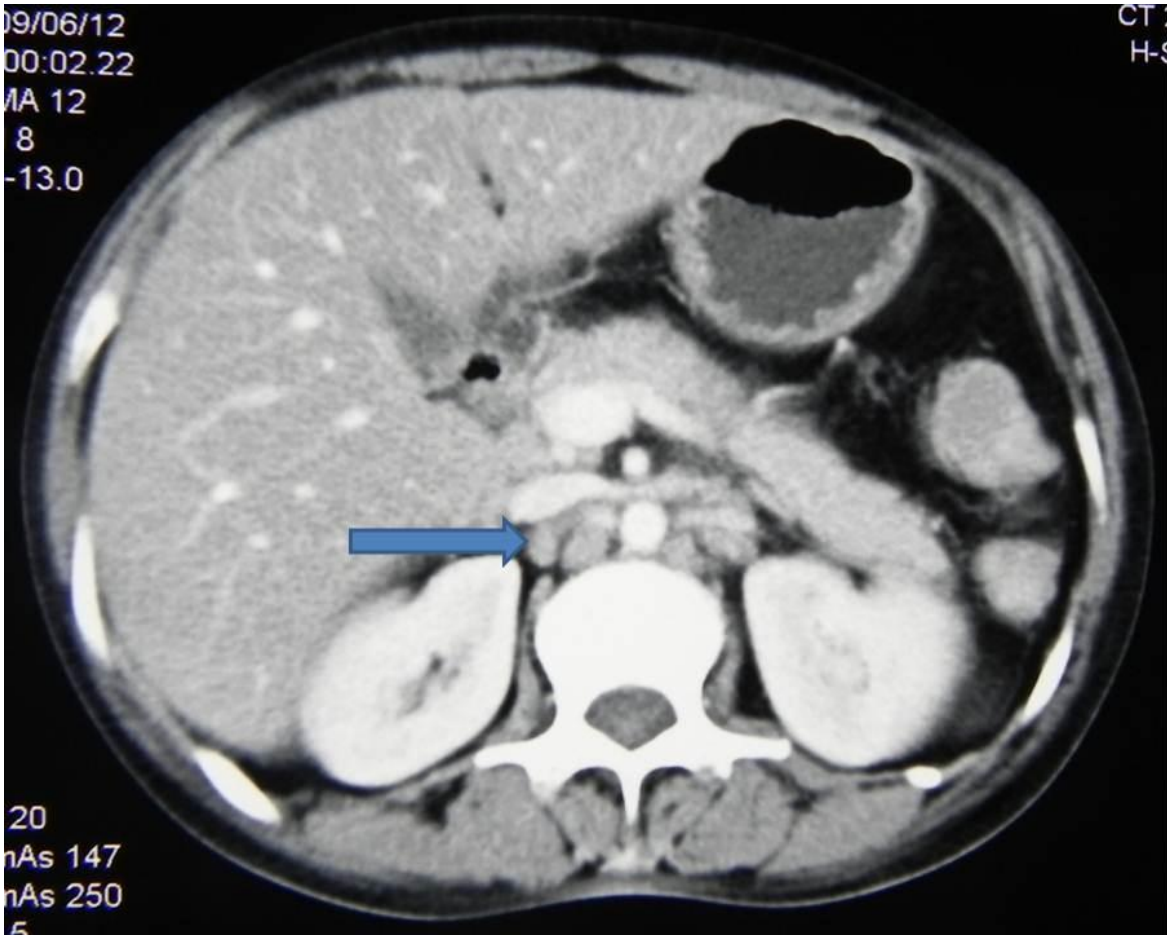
CT scan showing enlarged retroperitoneal lymph nodes (arrow), but no gland could be biopsied.
